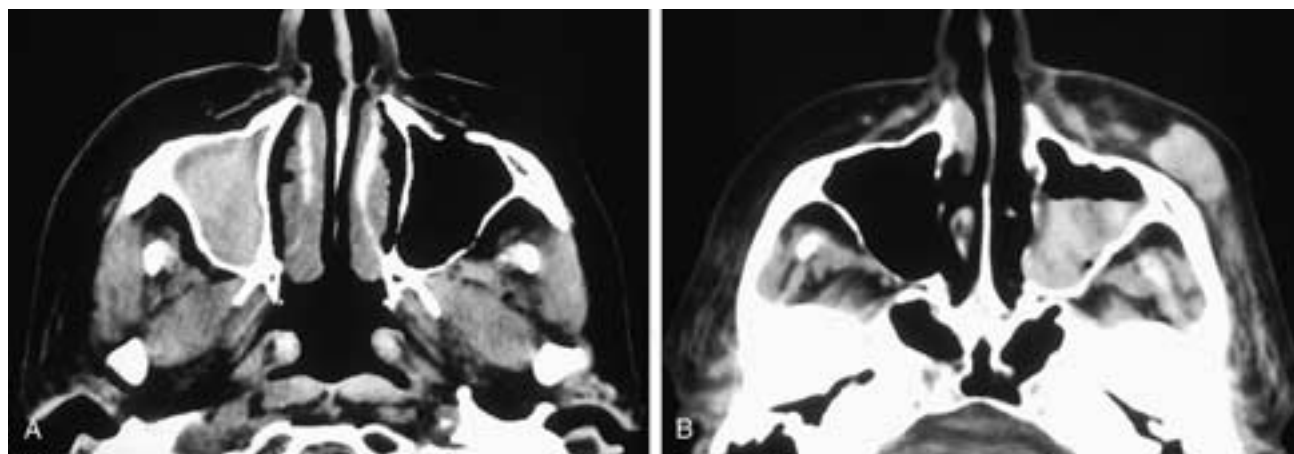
Axial CT scan (A) shows high-attenuation hemorrhage within the right maxillary sinus. There is slight fullness of the soft tissues in the right cheek area. This patient had received blunt trauma to the right face and presented with epistaxis. No fractures were present. Axial CT scan (B) on another patient shows high-attenuation fluid within the left maxillary sinus. There is also edema and a hematoma within the subcutaneous tissues of the left cheek. This patient was in the passenger seat during a low-velocity car accident and presented with a cheek deformity and epistaxis. No fractures were present.
